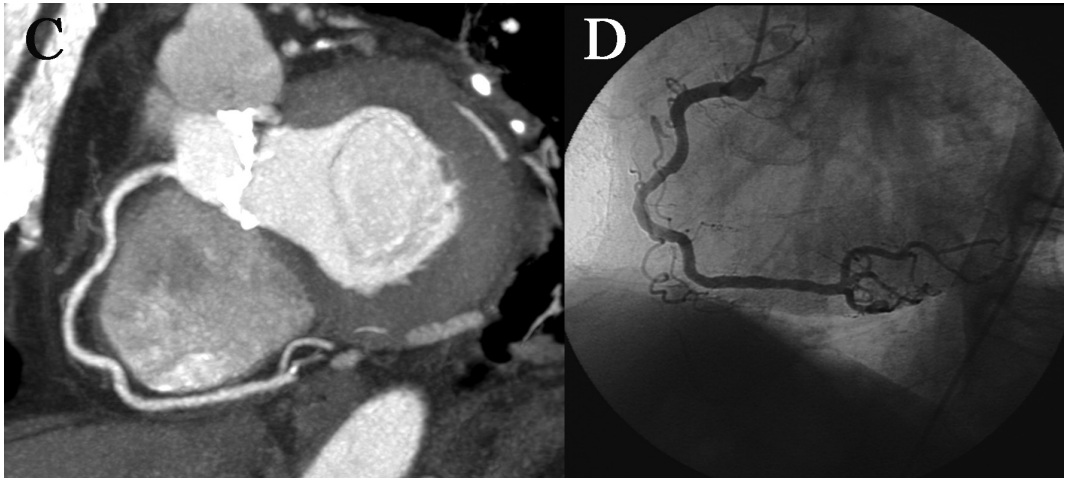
A CT image displays a patent right coronary artery without any signs of coronary artery disease (C). The bright white spots represent severe calcifications of the aortic valve. The CCA confirms the patency of the right coronary artery (D).
